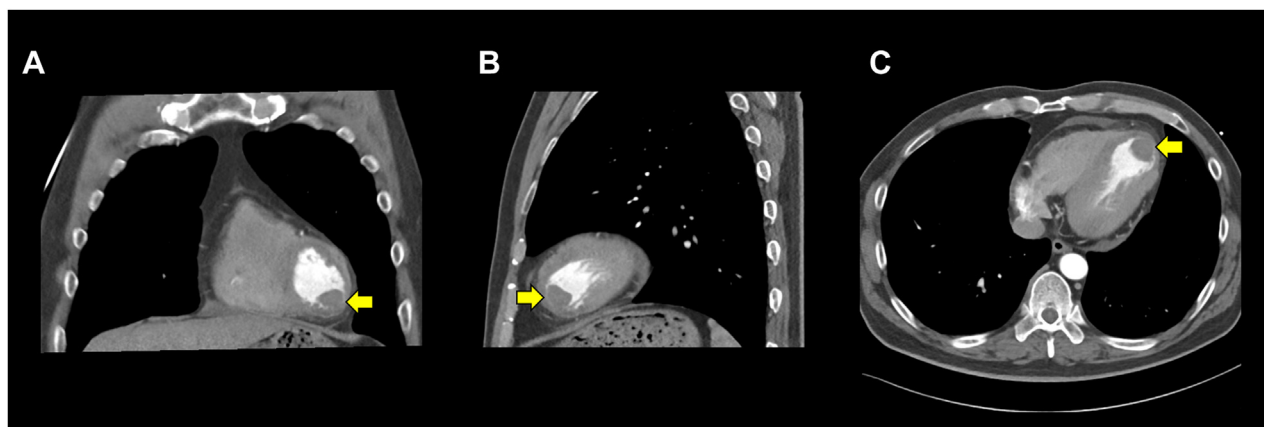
Contrast-enhanced computed tomographic images (day 13), multiplanar reformat in (A) coronal, (B) sagittal, and (C) axial displays, demonstrate a LV apical thrombus (arrows).
